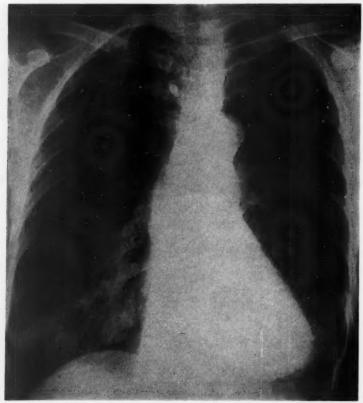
Case 14. Repeat chest x-ray 12/27/56. X-ray report: "The lungs are negative... the heart appears within normal limits... the aorta is elongated and tortuous with calcification in the knob." Note the deepening of the costophrenic angles in the successive x-rays. The true depth of the costophrenic sinuses is apparent only after the pleural fluid has disappeared.
